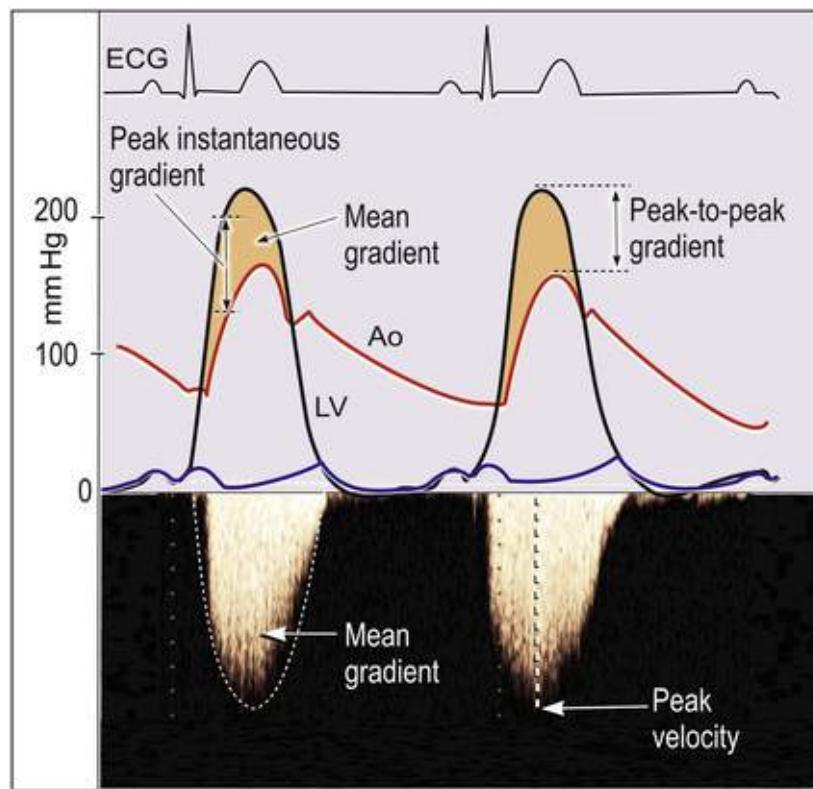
Doppler methods provide peak instantaneous and mean gradients. The peak instantaneous gradient is typically higher than the peak-to-peak gradient calculated from invasively measured peak left ventricular (LV) and aortic (Ao) pressure, which is not instantaneous, although mean gradients measured with both techniques are identical.
